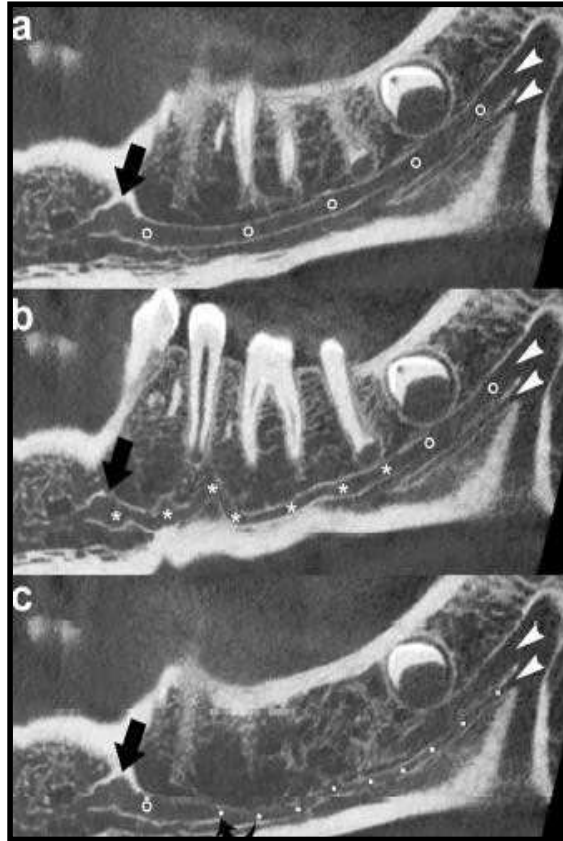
Pan CBCT images demonstrating the distomesial course of the three MC (MCmain, AMC1, AMC2). (a, c) The intra-mandibular course of MCmain (circles) and AMC2 (dots) forms an upward-facing curve. AMC2 joins MCmain at the level of the 2nd premolar (curved arrow). (b) The intra-mandibular course of AMC1 (asterisks) shows a serpiginous shape in its anterior portion. AMC1 originated from MCmain at the level of 2nd premolar. Double mandibular foramen is also shown (arrowheads). Large black arrows, mental foramen
